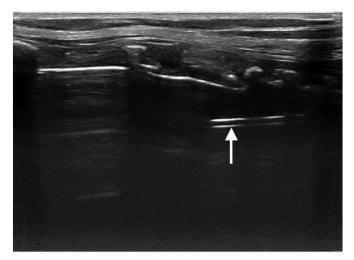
Sonographic appearance of a saline-filled ETT cuff (arrow).
